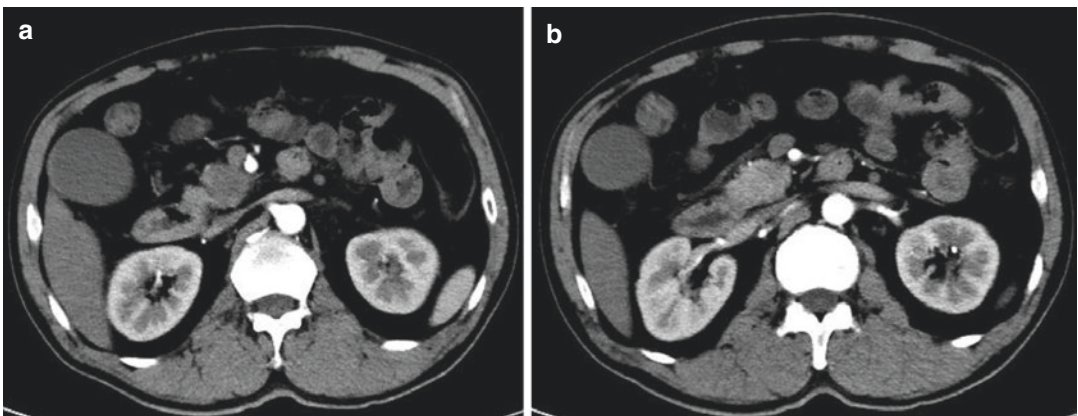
(a, b) CT image showed a mass in the ampullary region
